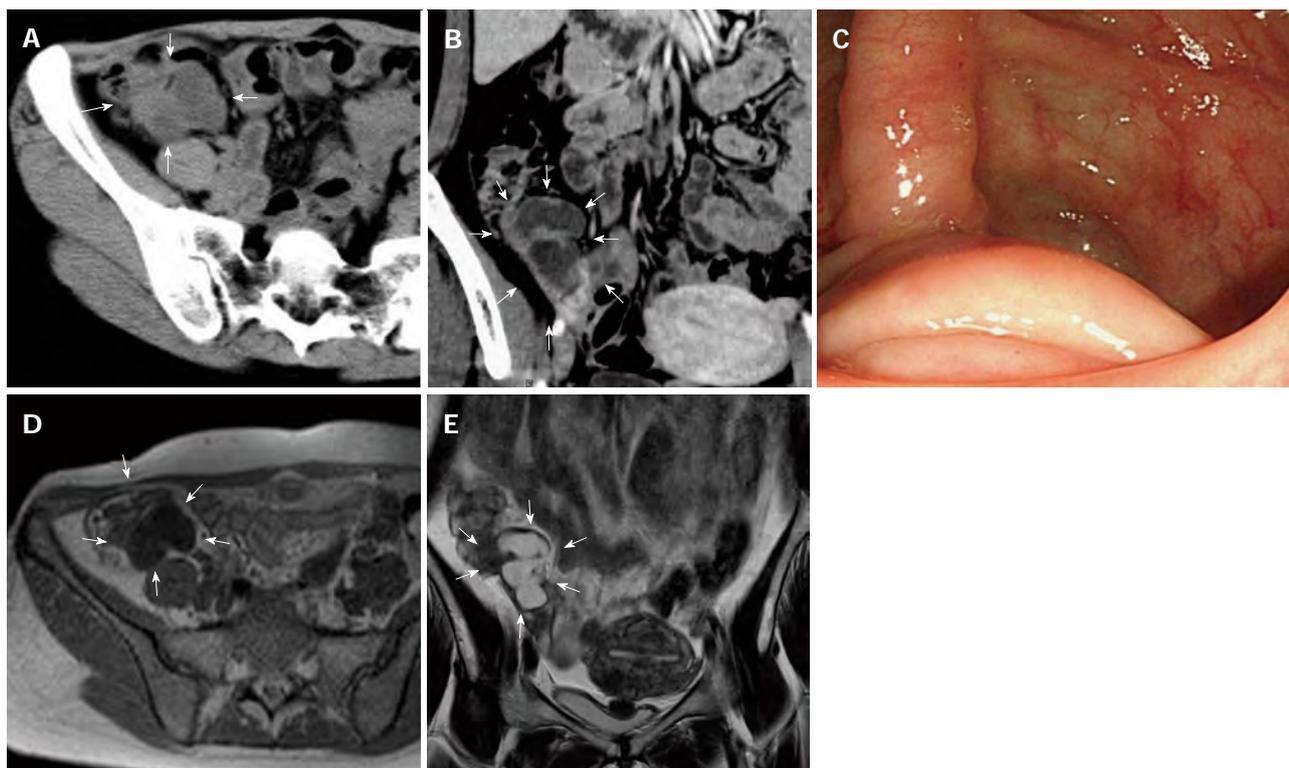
Preoperative image of the mucocele. A: Computed tomography (CT) (axial image); a tumor was detected (arrows); B: CT (coronal image); a tumor was detected (arrows); C: Colonoscopy; submucosal tumor-like elevations of the appendiceal orifice; D: Magnetic resonance imaging (MRI) (T1-WI, axial image); E: MRI (T2-WI, coronal image).
